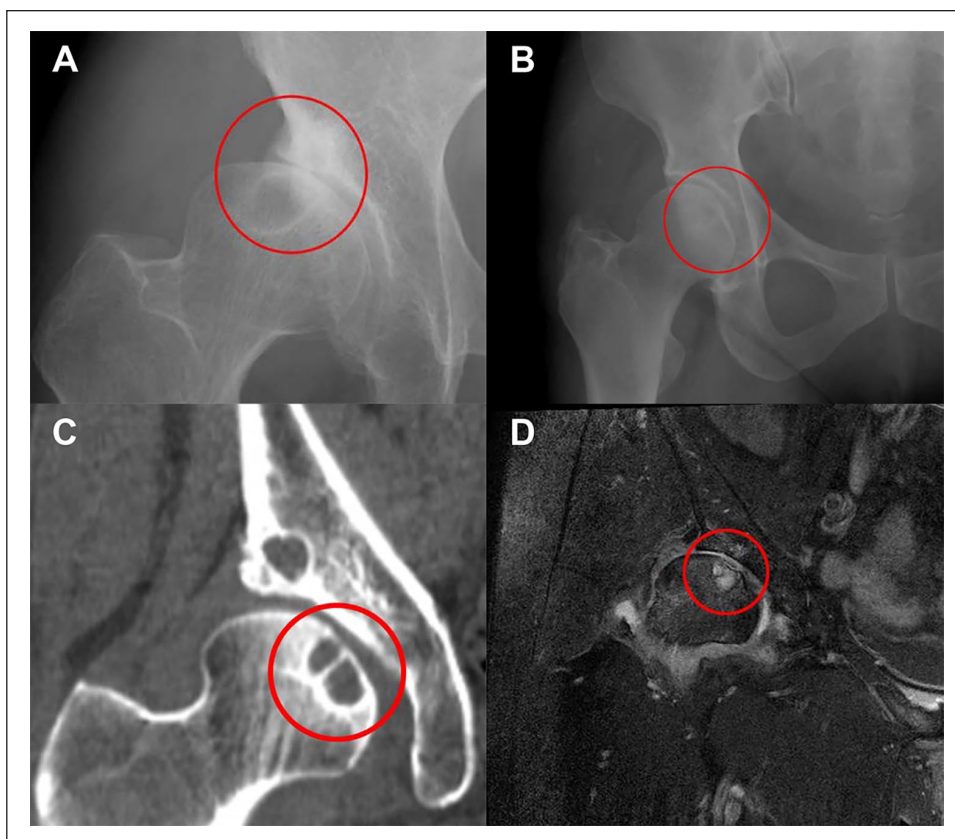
(A) Typical cyst at the lateral aspect of the femoral head, (B) Subchondral cyst at the medial aspect of the femoral head in hip dysplasia on x-ray, (C) CT, and (D) MRI.
